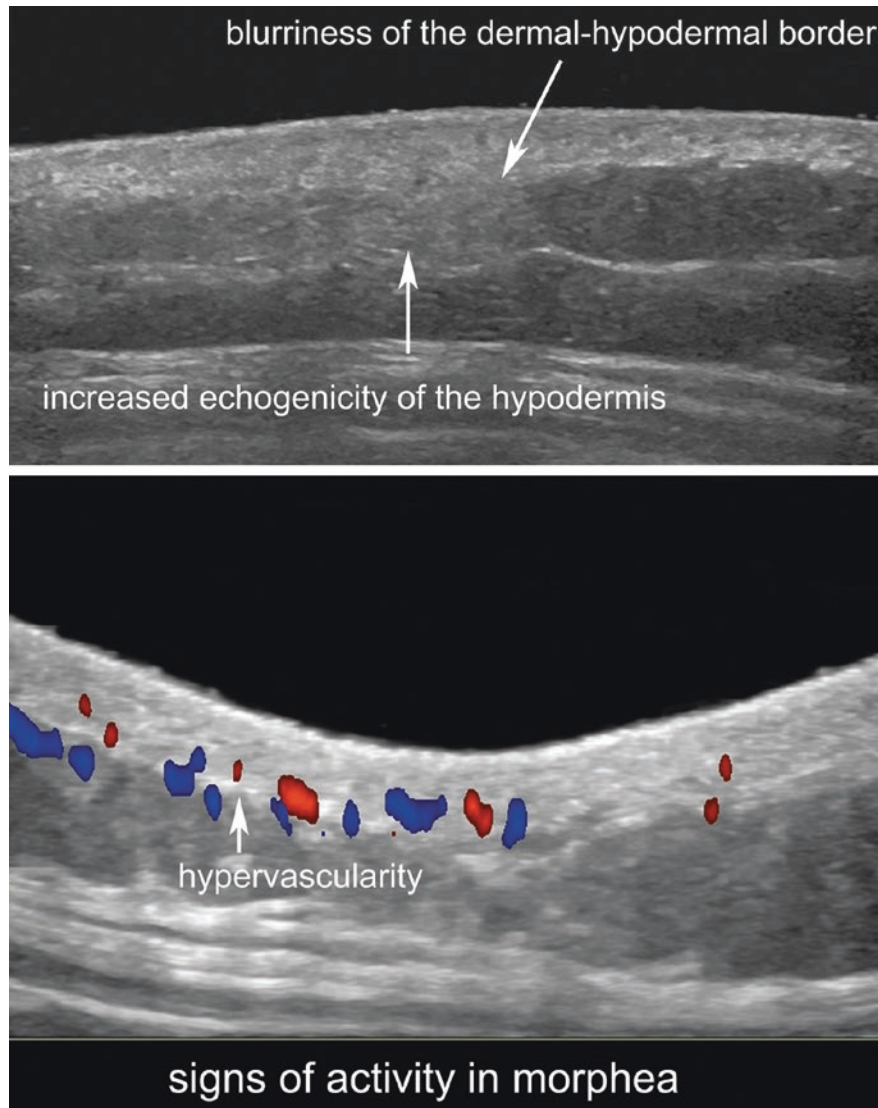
Sonographic signs of activity in morphea.
